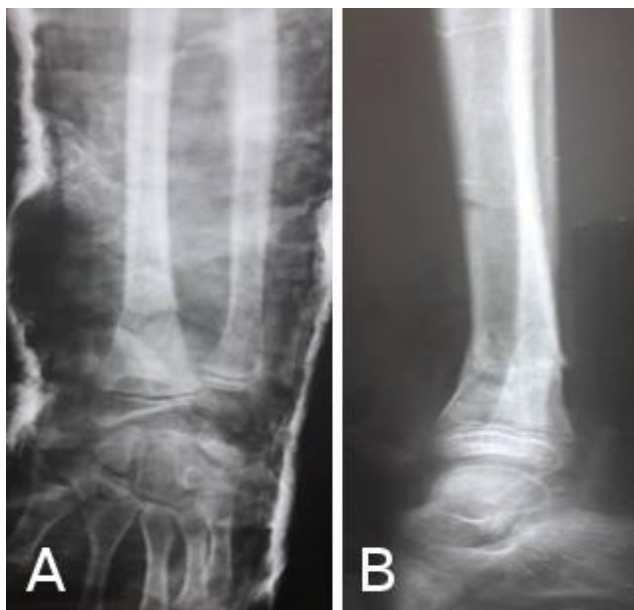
A postoperative anteroposterior (A) and lateral X-ray (B), showing the healed fracture of the distal radius
